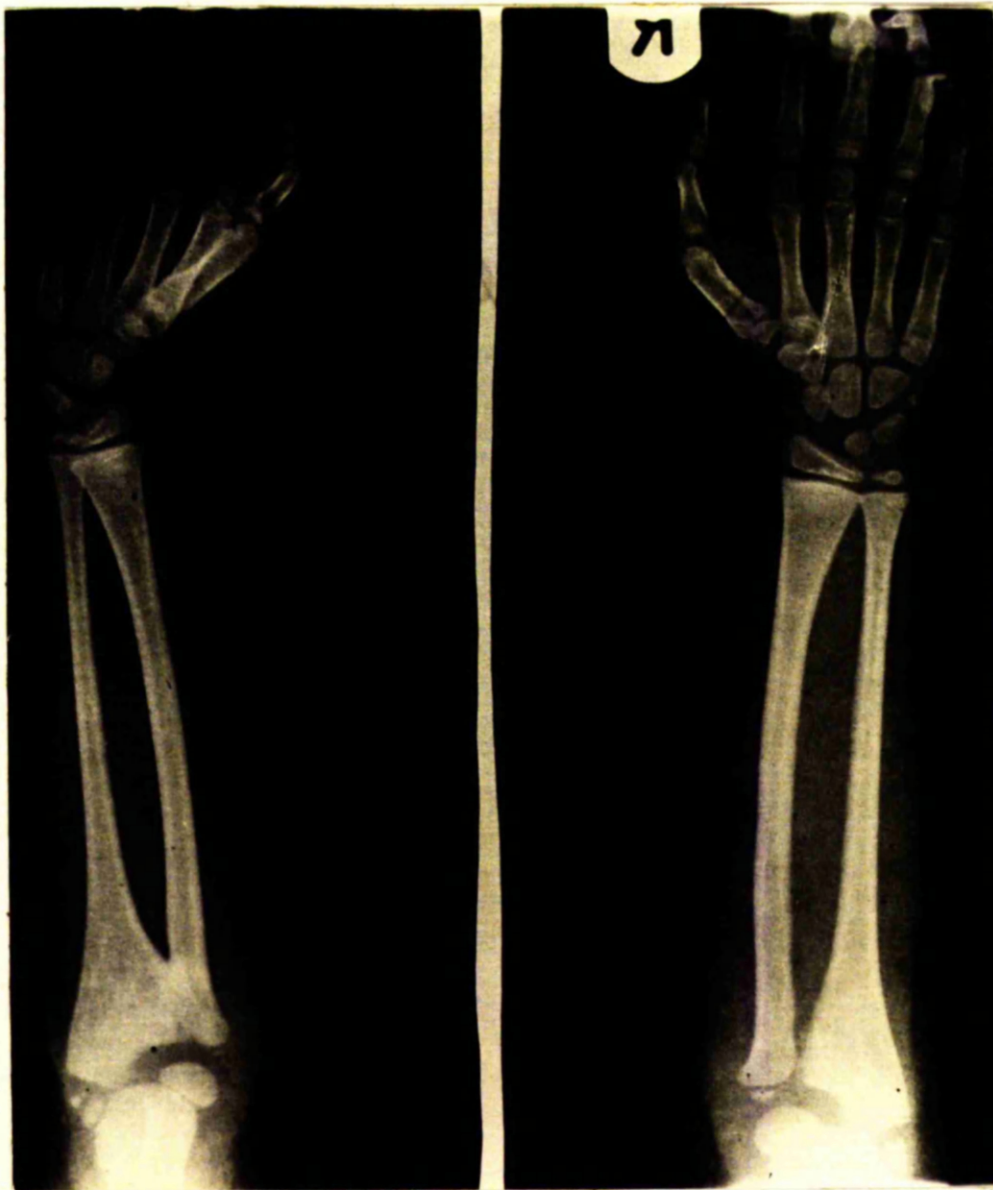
X-ray of forearms and elbow-joints showing a radio-ulnar synostosis on the left side and other deformities of the radius and ulna.
